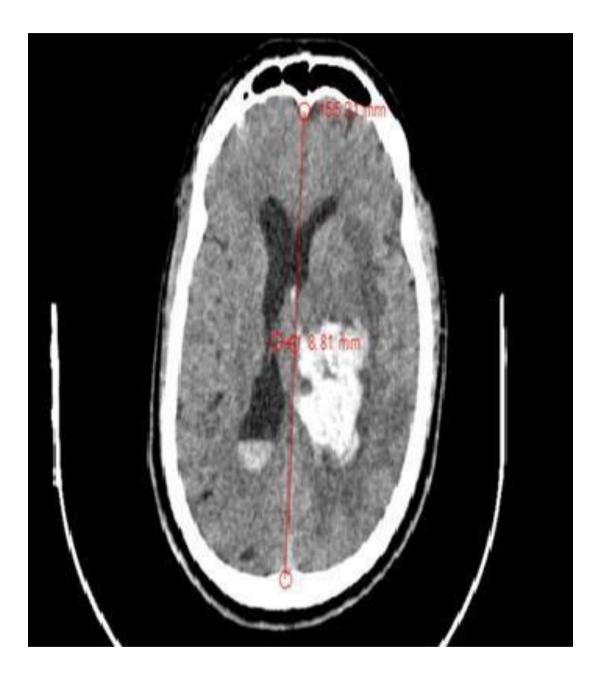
Axial non contrast enhanced brain CT showing a large Intra-parenchymal hemorrhage in the left capsulo-ganglionic region causing mass effect over ipsilateral lateral ventricle and midline shift of 8 mm to right with Intraventricular hemorrhage
